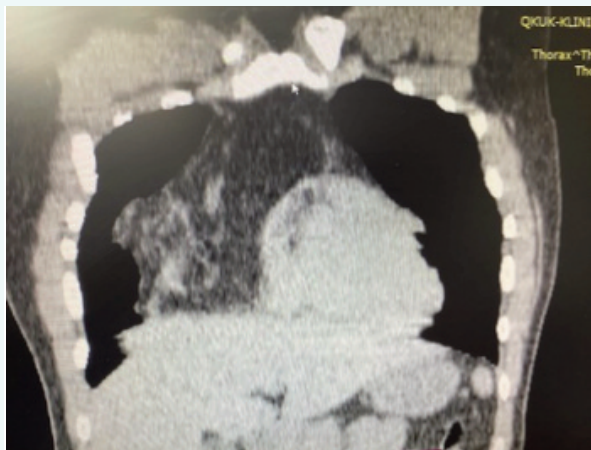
CT of tumour mass in the right mediastinum
